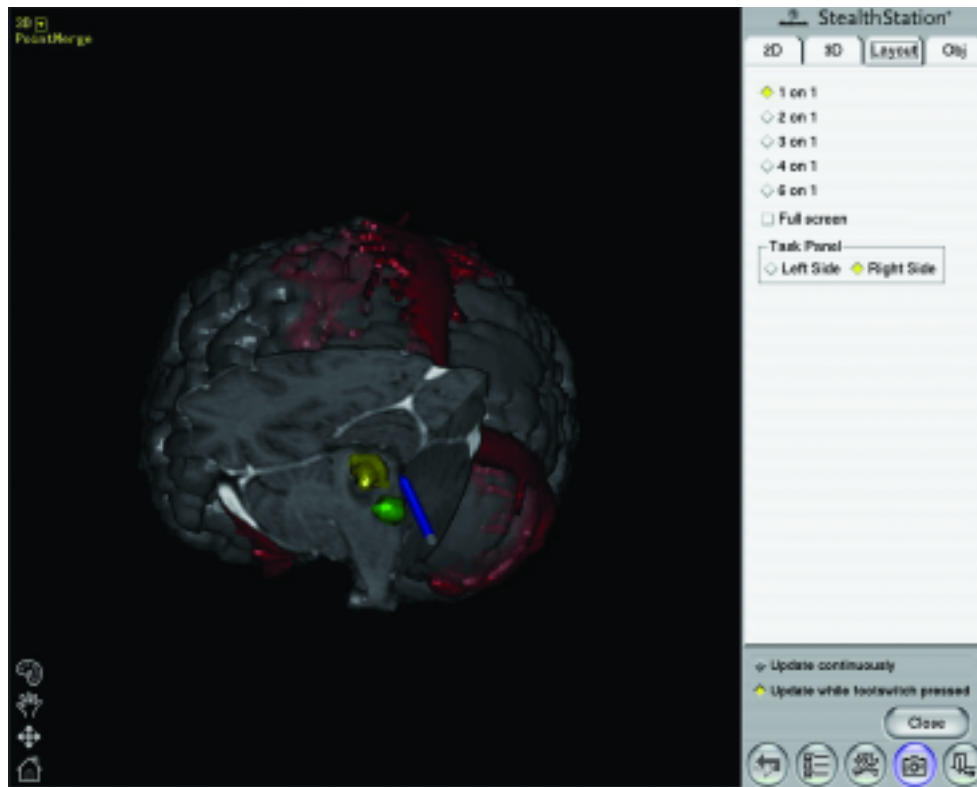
Three-dimensional model of a human brain adapted from a magnetic resonance image, showing the potential for creating pathophysiologies on a neuronavigator workstation.
